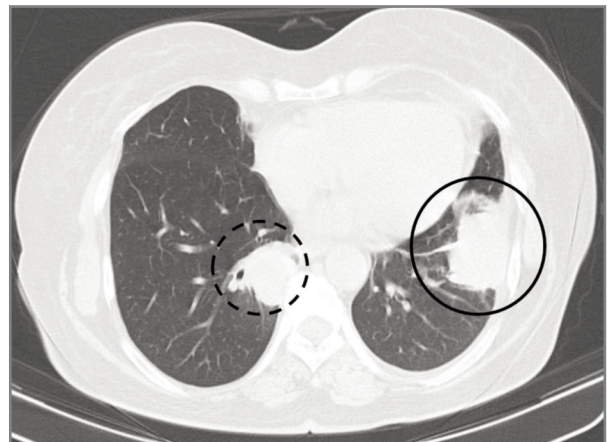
Chest computed tomography showing persistent left lower lobe nodule (continuous line) and a new right paravertebral pulmonary nodule (dashed line)
